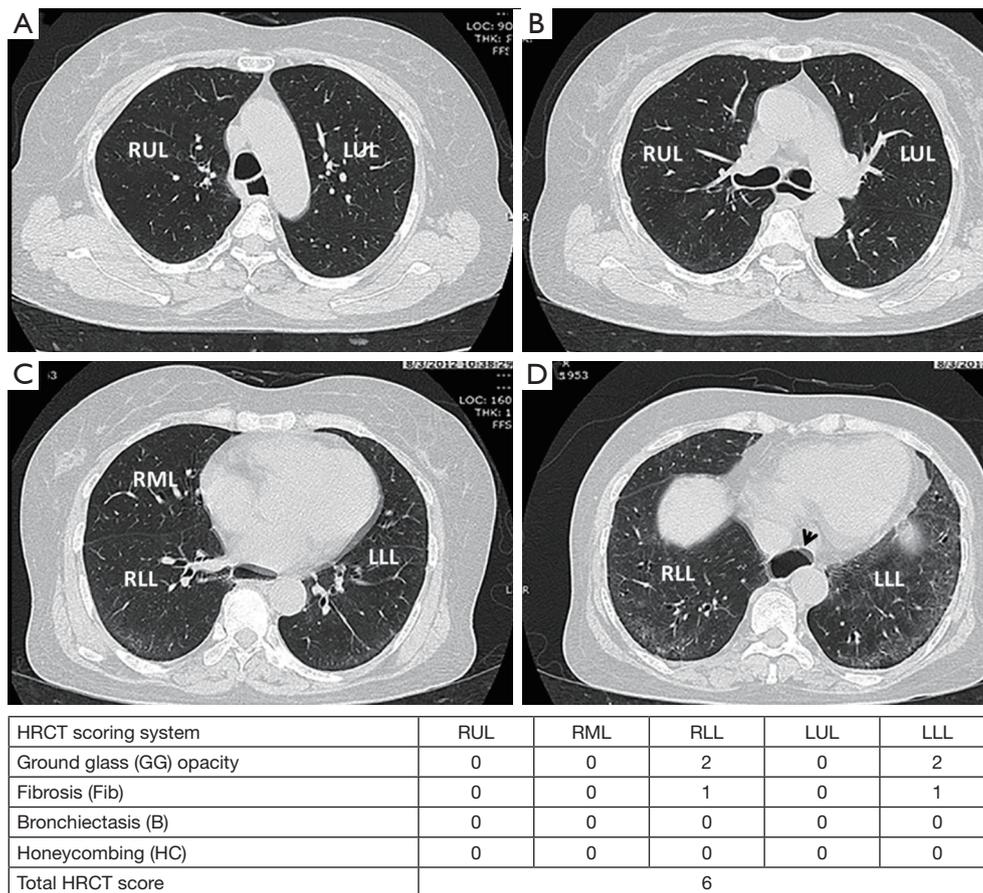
Four high-resolution computed tomography (HRCT) images in a 58-year-old man with dcSSc at level of aortic arch (A); carina (B); inferior pulmonary vein (C) and lung base (D) reveals bilateral peripheral ground glass (GG) opacities with fine reticulation (Fib) and relative subpleural sparing, which compatible with early fibrotic nonspecific interstitial pneumonitis (NSIP) pattern. There was esophageal dilatation (arrow head).
